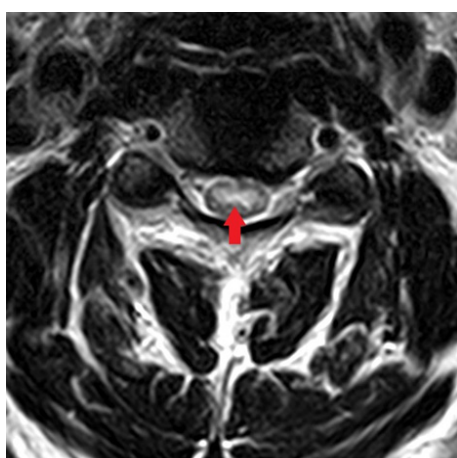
Axial T2WI MRI (magnified view) at the cervical cord level demonstrated the abnormal high T2 signal abnormality of the anterior spinal cord with the owl-eyes sign (red arrow)
